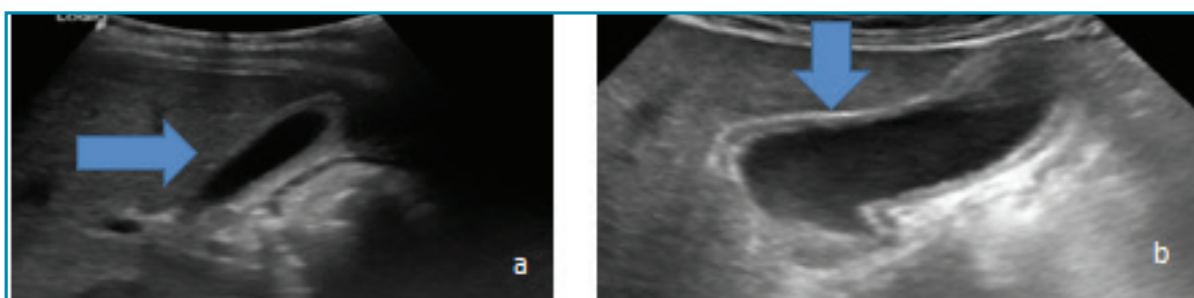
Gall bladder evaluation by ultrasonography.a) oedematous gall bladder wall (horizontal arrow).b). pericholecystic fluid collection (vertical arrow).
